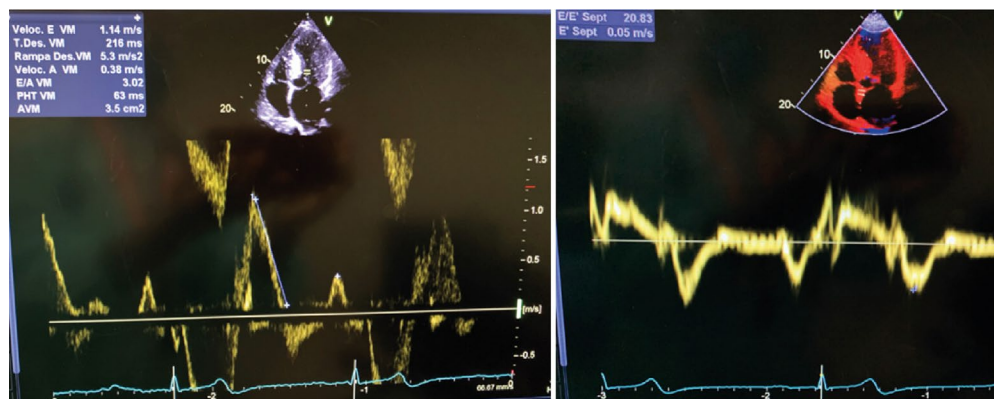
Doppler images of the left ventricle of a patient with advanced fabry cardiomyopathy. A. transmitral flow pulsed wave doppler showing an increased e/a ratio. B. mitral ring tissue doppler in the septal position with a decreased propagation velocity and increased e/e' ratio. Both changes are compatible with a left ventricle diastolic dysfunction pattern.
